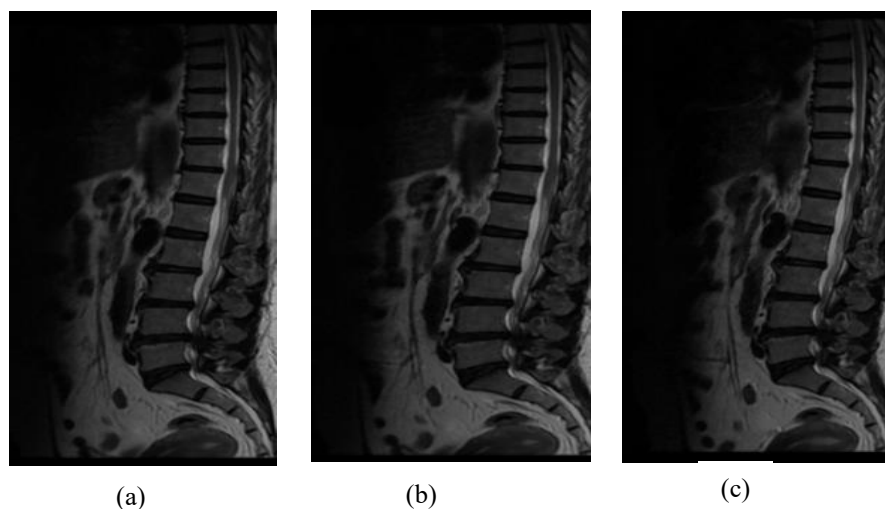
Clinical HNP Thoracolumbar Sagittal T2 FSE MRI Image Results (a) ARC 1 (b) ARC 1.5 (c) ARC 2
